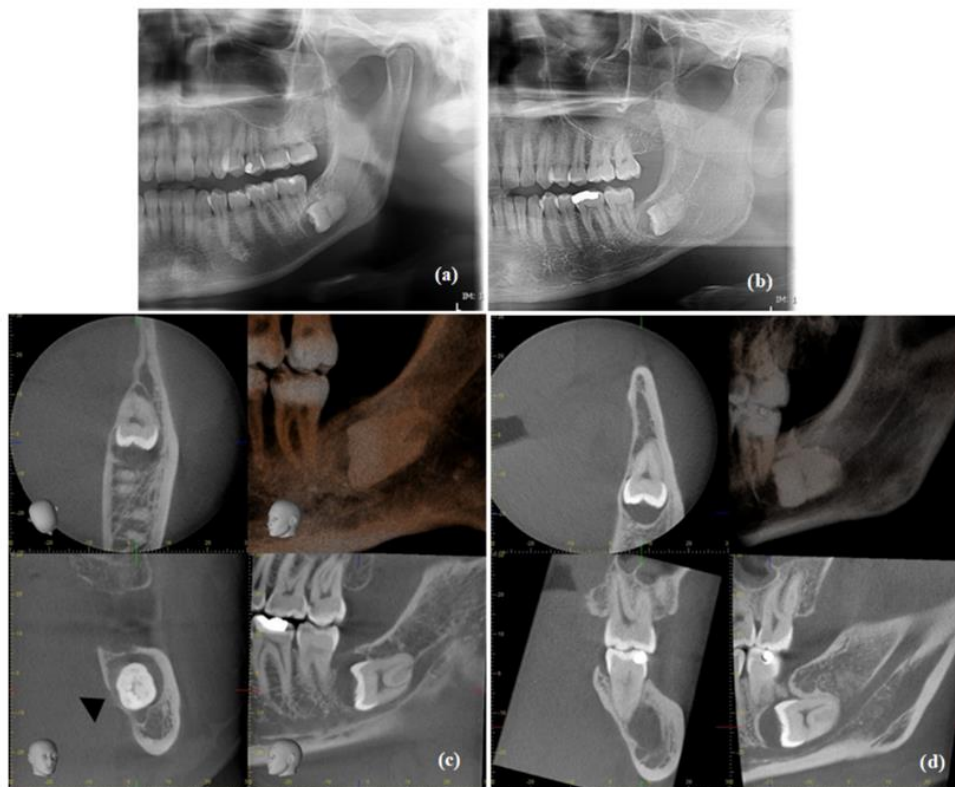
Cropped panoramic radiographs show that dentigerous cyst (a) and hyperplastic dental follicle (b) may appear identical in terms of pericoronal width and their relationship to nearby structures. However, CBCT shows that dentigerous cysts exhibit distinct bone expansion with thinning of the lingual cortical plate-black arrowhead (c), whereas hyperplastic dental follicles do not (d).
